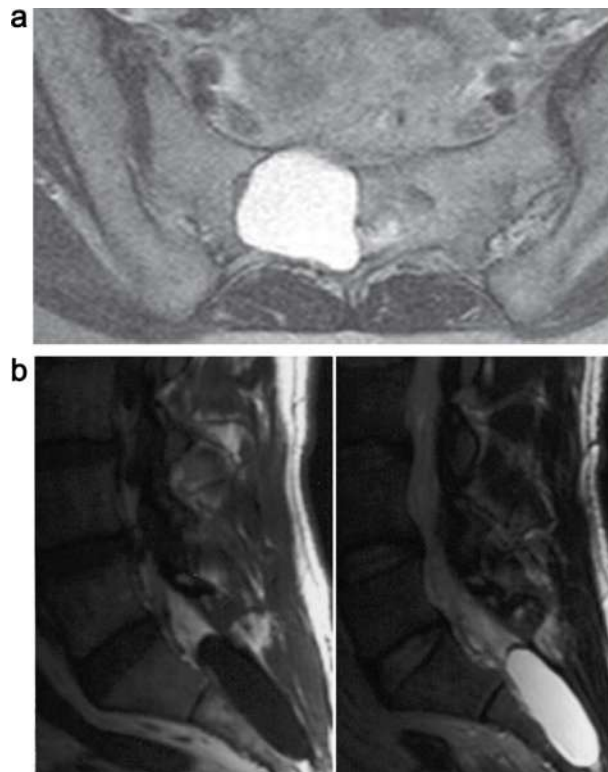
a: Tarlov cyst, with substantial bone erosion and compression of the right S2 nerve to the wall of the cyst in 9 o'clock position (T2 weighted MRI, axial view through sacrum). b: Large S2/S3 Tarlov cyst, T1 weighted view, Tarlov cyst on T2 weighted view (Sagittal MRI views through the sacrum).
